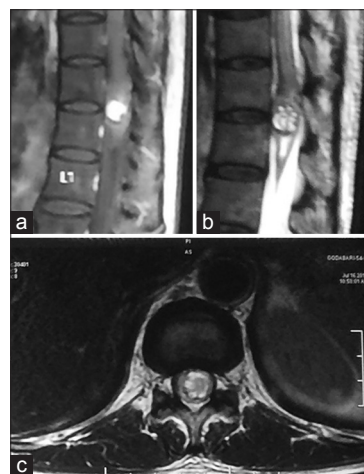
The MRI scan of the thoracic spinal cord: Sagittal (a) T1-weighted contrast image, sagittal (b) T2-weighted image, axial (c) T1-weighted contrast image and axial: Showing a solitary mass in the intramedullary spinal cord at D11-12 level. The lesion showed a heterogeneous enhancement following intravenous gadolinium contrast
